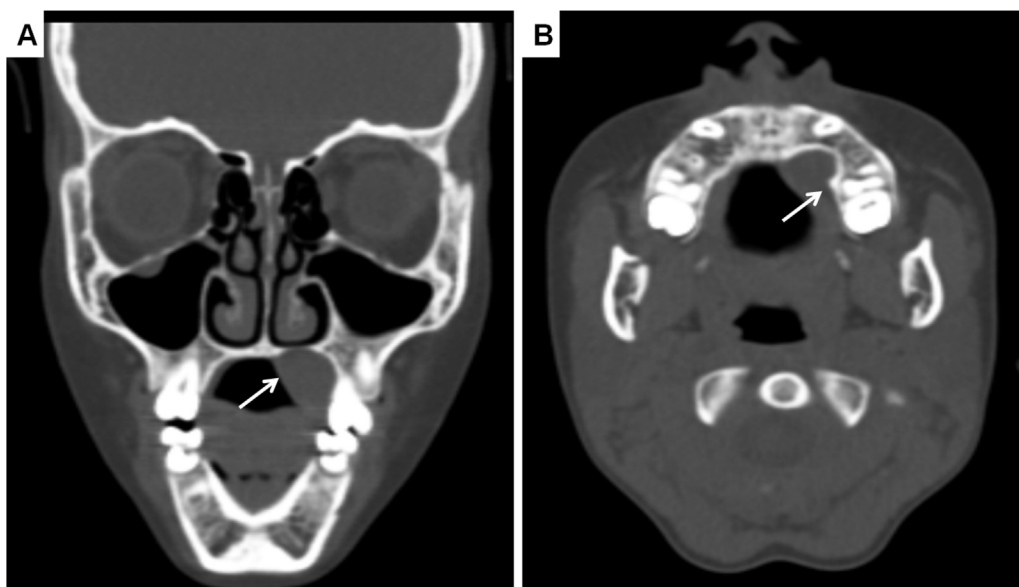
(A) Frontal CT shows hypodense mass (arrow) with proximity to the nasal cavity. (B) Axial CT shows osseous resorption in maxilla.
